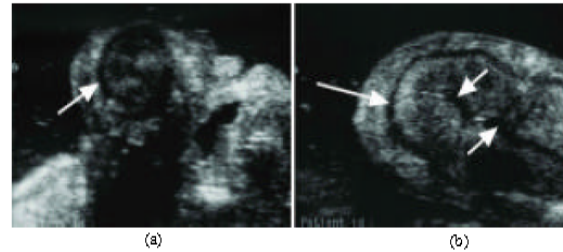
Ultrasonographic evaluations normal uterus (arrow), uterus with chronic endometritis. Accumulation of uterine fluid (small arrows). Uterine wall (long arrow)
